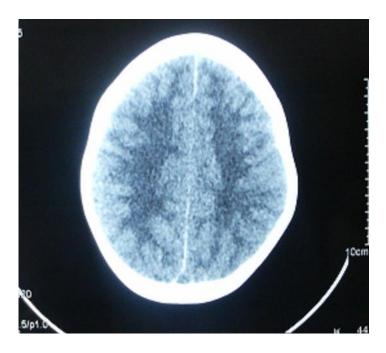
CT of one of the patients with severe brain edema with effacement of sulci of the brain
